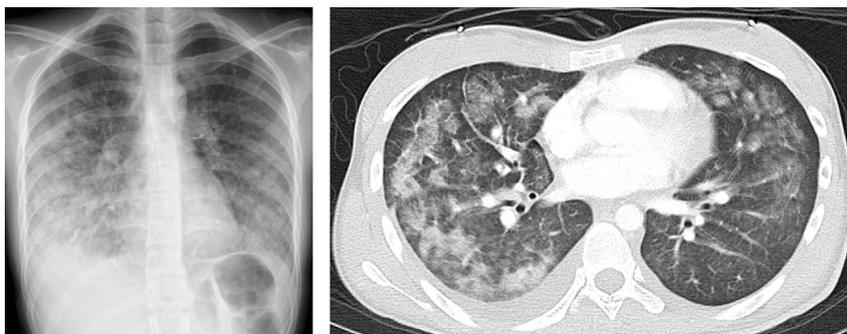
Chest radiograph (left) and CT imaging (right) for Case 1. The chest X-ray and CT scan revealed wide-spread ground-glass opacities along the bronchovascular bundles and bilateral pleural effusions.
